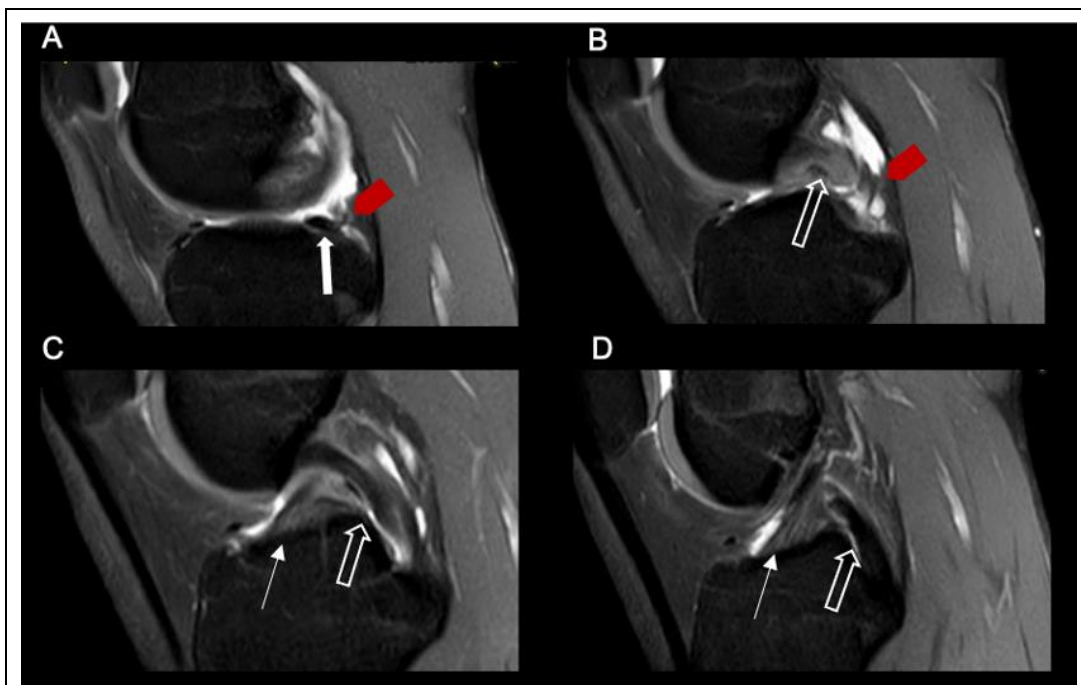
(A-D) MRI: Sagittal DP fat saturation weighted image from medial to lateral revealing an accessory connection (red arrowhead) between PCL (empty arrow) and the medial meniscus posterior horn (white arrow). ACL (white thin arrow).
